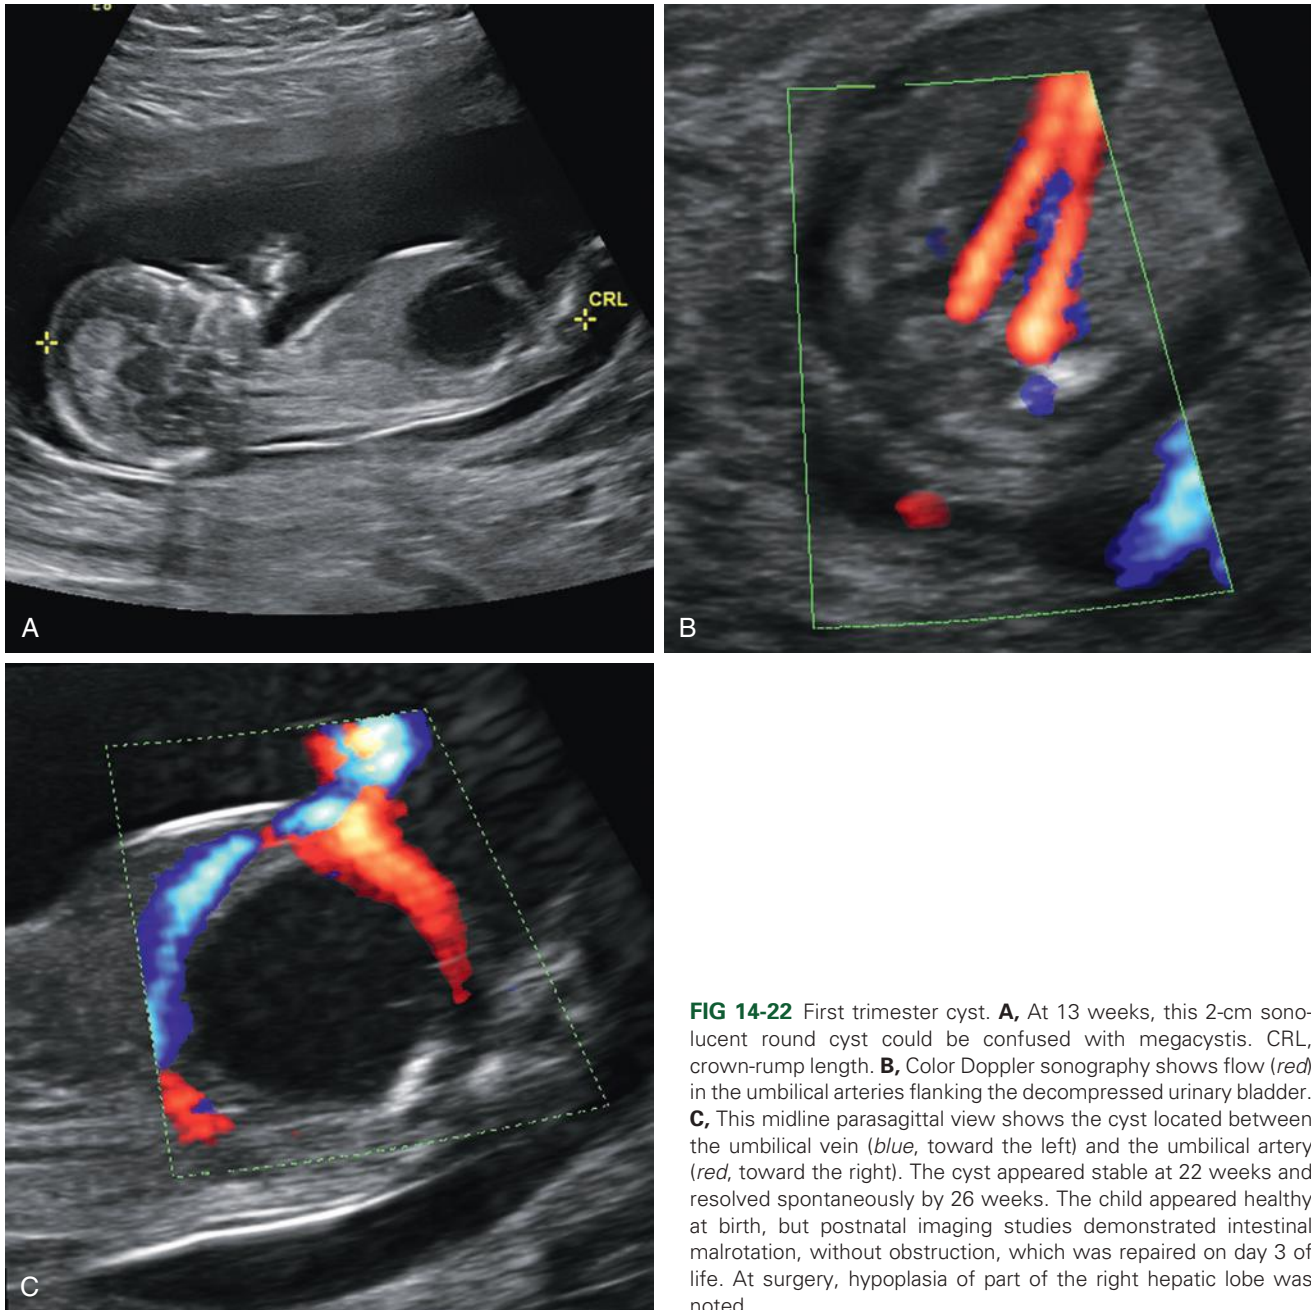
First trimester cyst. A, At 13 weeks, this 2-cm sonolucent round cyst could be confused with megacystis. CRL, crown-rump length. B, Color Doppler sonography shows flow (red) in the umbilical arteries flanking the decompressed urinary bladder. C, This midline parasagittal view shows the cyst located between the umbilical vein (blue, toward the left) and the umbilical artery (red, toward the right). The cyst appeared stable at 22 weeks and resolved spontaneously by 26 weeks. The child appeared healthy at birth, but postnatal imaging studies demonstrated intestinal malrotation, without obstruction, which was repaired on day 3 of life. At surgery, hypoplasia of part of the right hepatic lobe was noted.
